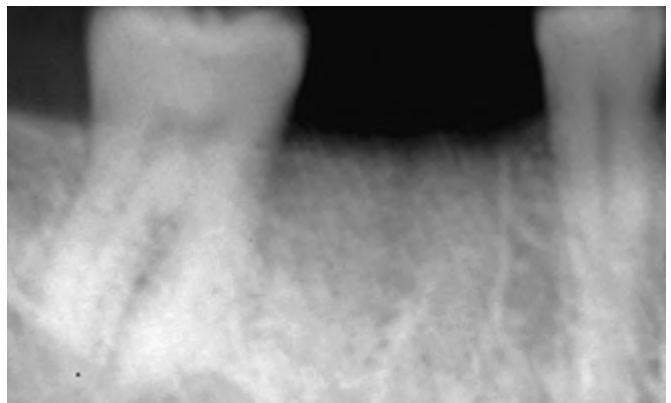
Radiograph taken 4 months post extraction and bone grafting. The bone graft appeared to be successful, and the site appeared ready for implant placement.
